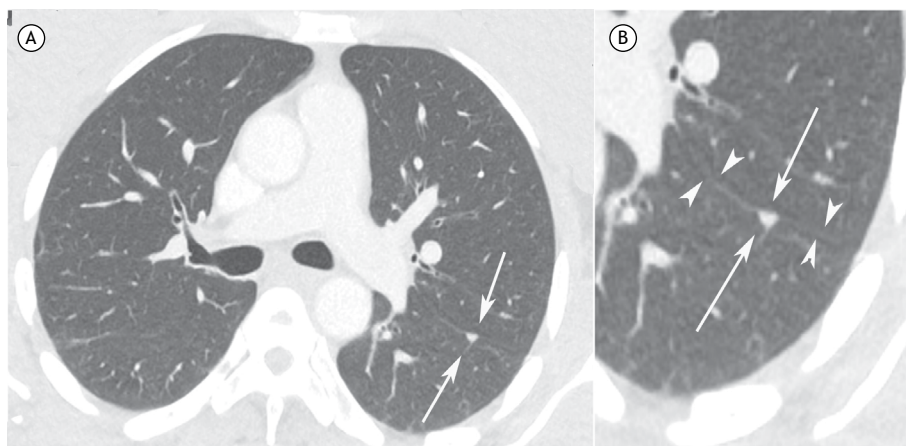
In A, axial CT image of the chest (lung window) showing a small triangular-shaped nodule in the posterior region of the left lung, closely related to the pleural fissure. In B, detail at higher magnification of the aforementioned nodule, clearly characterizing the triangular shape of the intrapulmonary lymph node (arrows) and its close relationship with the oblique fissure (arrowheads).
